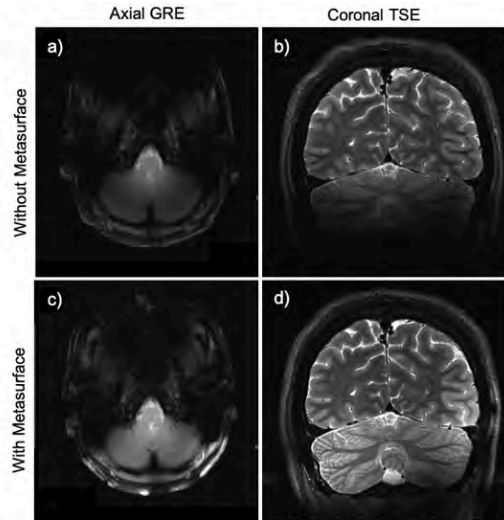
In-vivo brain MRI at 7T. Axial GRE and coronal TSE images obtained without (top row) and with (bottom row) the metasurface show significant SNR improvement in the inferior regions in the presence of the metasurface, particularly in the cerebellum and brainstem.
